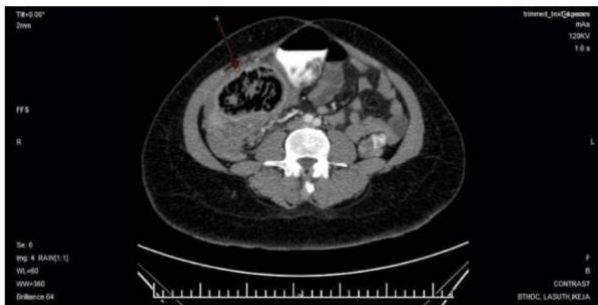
Contrast enhanced axial CT image at the level of the aortic bifurcation shows a hypodense mass (red arrow) on the right-side containing gas bubbles and a thin enhancing capsule.
